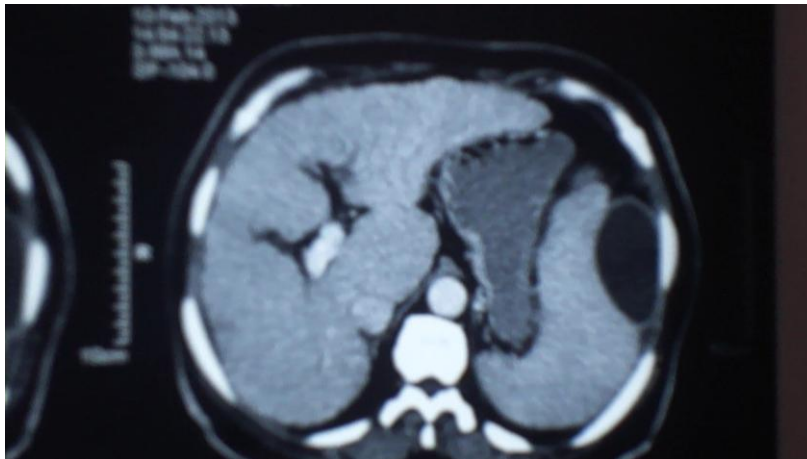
Abdominal CT scan showing splenic subcapsular abscess
